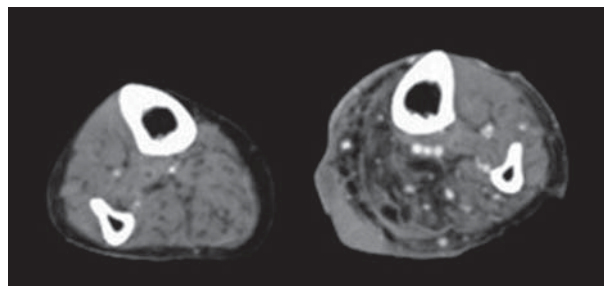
Although increased soft tissue density was observed below the skin in the right lower leg, this did not extend to the inside of the muscle (enhanced computed tomography). Blood flow was relatively maintained.
